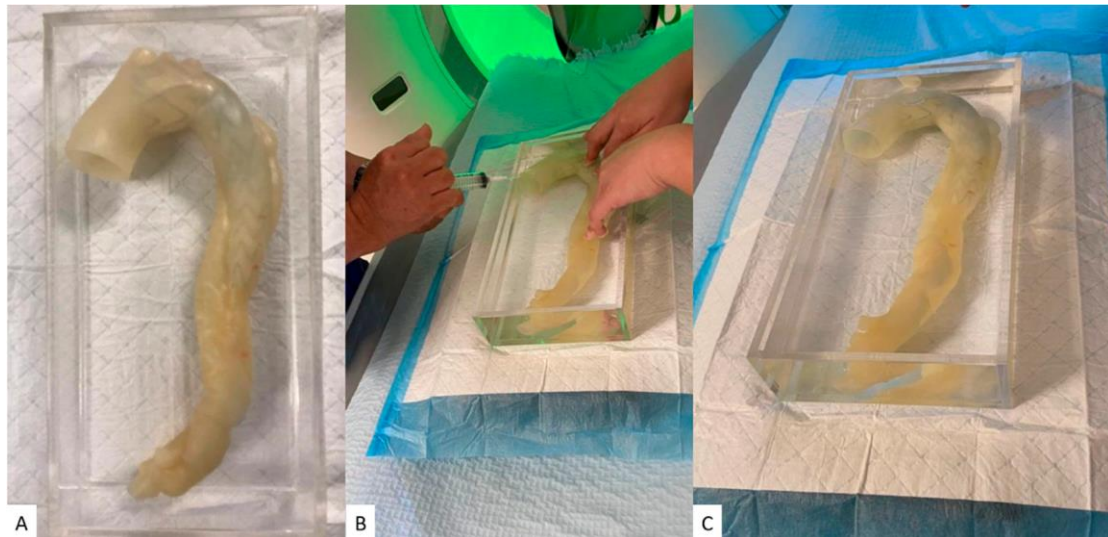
The CT scans were performed on the post stent graft deployed aorta model with different scanning protocols. (A) The model placed in a customized acrylic box for scanning. (B) The process of using the syringe to extract the internal air bubbles after pouring the contrast. (C) The final model ready to be scanned.
